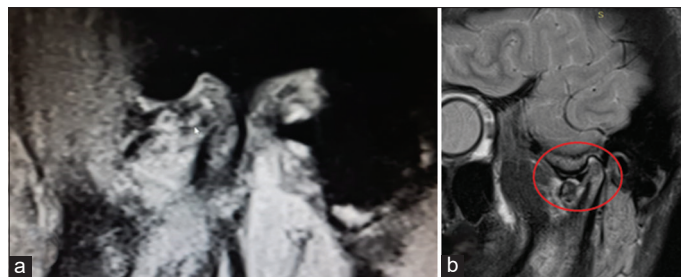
Screening magnetic resonance imaging (MRI) showing the tear in the articular disc. MRI of (a) case 1 and (b) case 2
